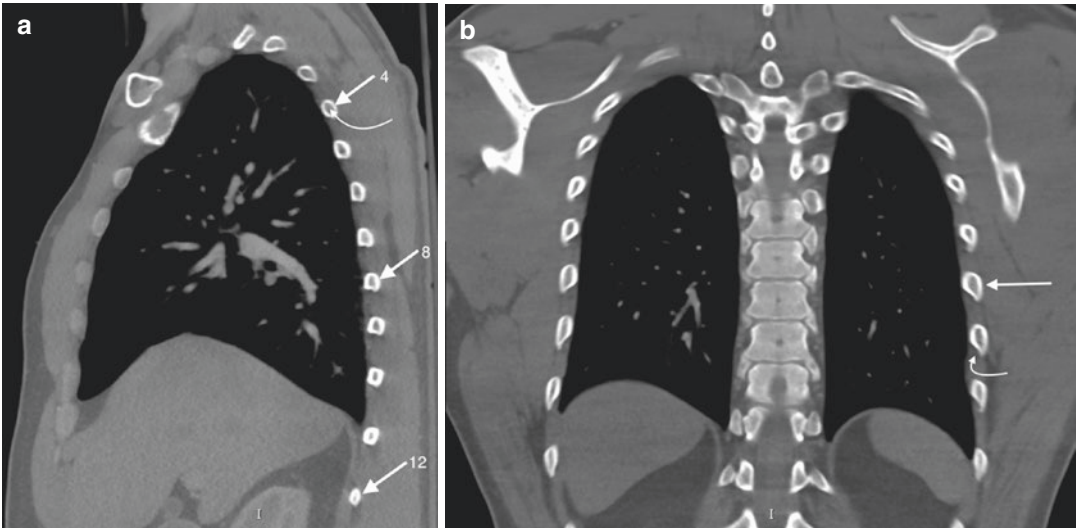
CT cross-sectional appearance of the rib shaft. Reformatted sagittal CT image (a) shows sagittal cross sections of the ribs (arrows). The margin of the rib is comprised of an oval-shaped thick cortical layer of bone that
